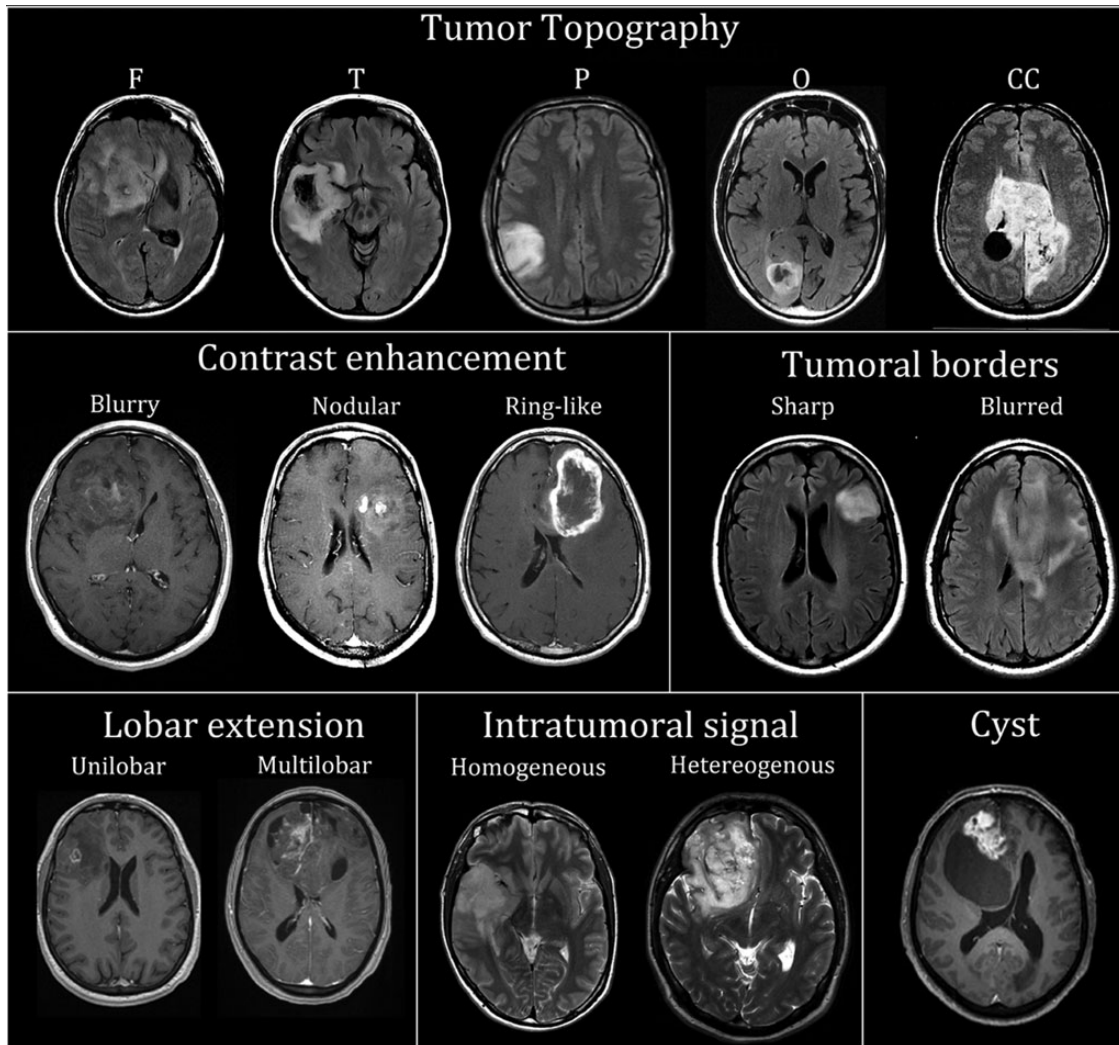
A representative example of the MRI features assessed in the 50 AOs. Upper panel: tumor topography—F: frontal, T: temporal, P: parietal, O: occipital, CC: corpus callosum. Middle panel: Contrast enhancement types (left), tumor borders in T2/FLAIR sequences (right). Lower panel: Lobar extension—unilobar or multilobar, intratumoral signal, cyst (diameter >1 cm).
